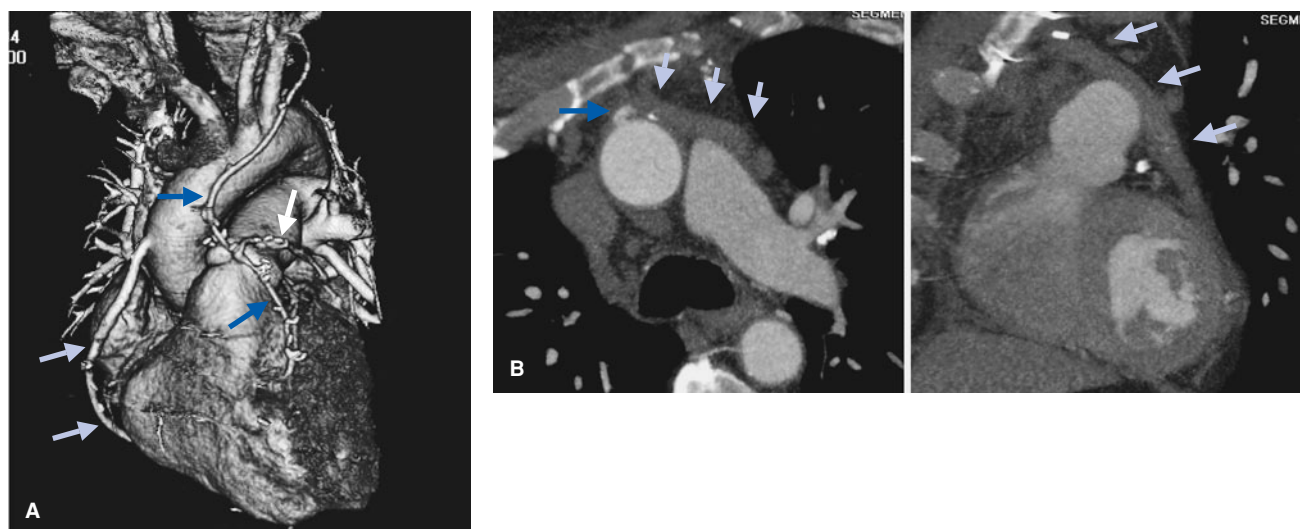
Cardiac CT performed for evaluation of graft patency in the postoperative setting. Three-dimensional volume-rendered image demonstrates patent left IMA to LAD (*blue arrows*), T-graft right IMA to obtuse marginal (*white arrow*), and SVG to RCA (*gray arrows*). This study was obtained in a patient 1 day following off-pump CABG. The patient had developed recurrent chest pain and elevated troponin. Cardiac CT ruled out early graft failure as a cause for the patient's presentation. Oblique multiplanar reformatted images (*B*) in a second patient demonstrate an acutely occluded saphenous vein graft to obtuse marginal. Note the patent graft stump (*blue arrow*) and thrombosed graft body (*gray arrows*).
